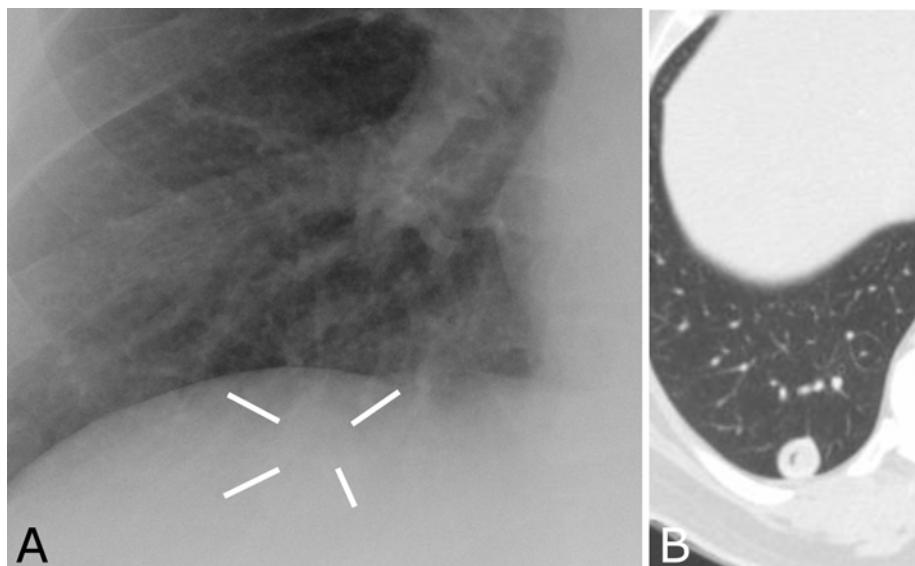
Lung nodule “below” the diaphragm. A. Frontal radiograph shows that the lung nodule (white lines) projects below the highest part of the diaphragm. B. Axial CT image shows that the lesion is within the posterior inferior part of the lung.
